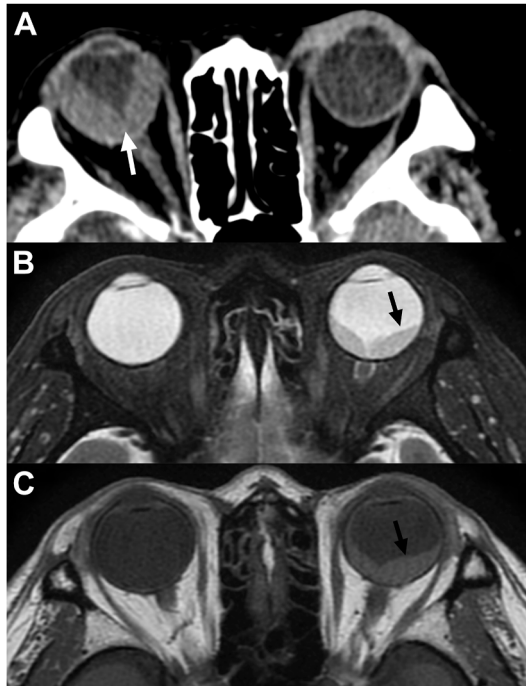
(A) Unenhanced CT showing a right retinal detachment and V-shaped hyperdense subretinal fluid (white arrow) extending from the ora serrata to optic disc. (B) Axial T2-weighted fat-suppressed and (C) axial T1-weighted MR sequences in another patient demonstrates a left retinal detachment (black arrows) with T2-weighted and T1-weighted hyperintense subretinal fluid.
